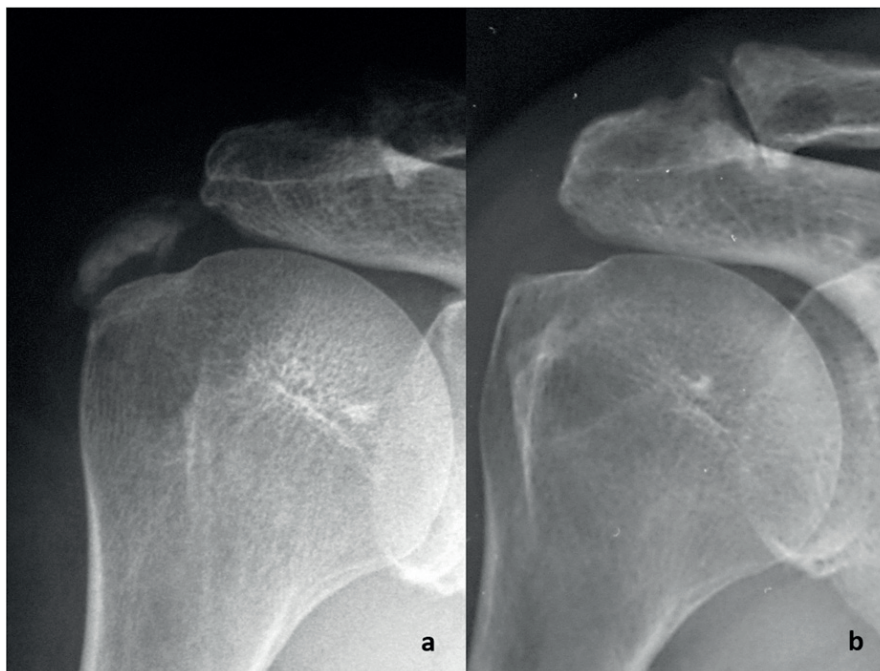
Anteroposterior radiographs of a right shoulder with a Gärtner type-II calcification of the supraspinatus before focused shockwave treatment (Fig. 3-A) and at 3 months after treatment (Fig. 3-B), showing that the calcification has disappeared.
